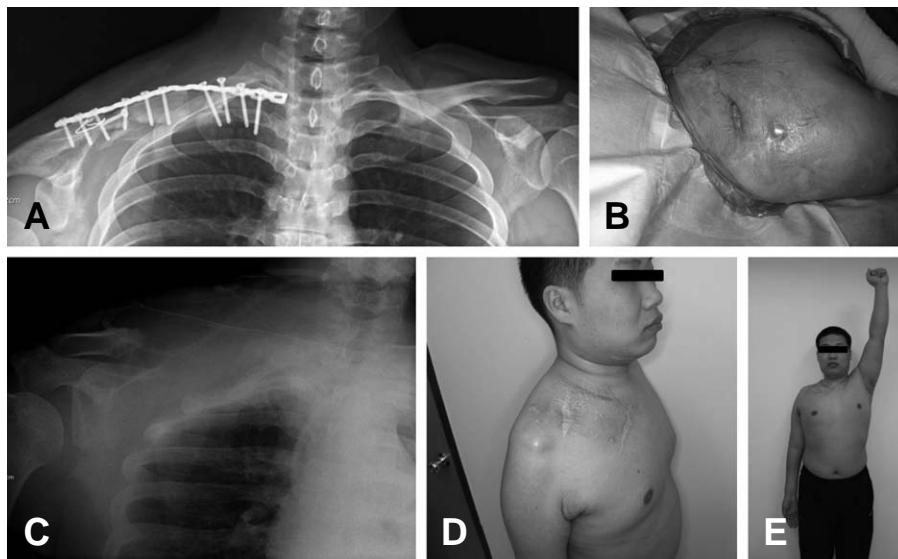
A 26 year old male patient with a case of infected nonunion (A) The initial radiograph taken upon entry into our hospital after two prior surgeries, showing large segmental bone defect and fixation failure (B) Photo showing skin fistula with puss discharge (C) Postoperative radiograph showing removal of dead bone and failed implant (D) Postoperative photo at 1.5 years, showing recovery of skin wounds, resulting in infection control (E) Patient at 1.5 years postoperation, showing lack of shoulder motion due to associated brachial plexus injury.
